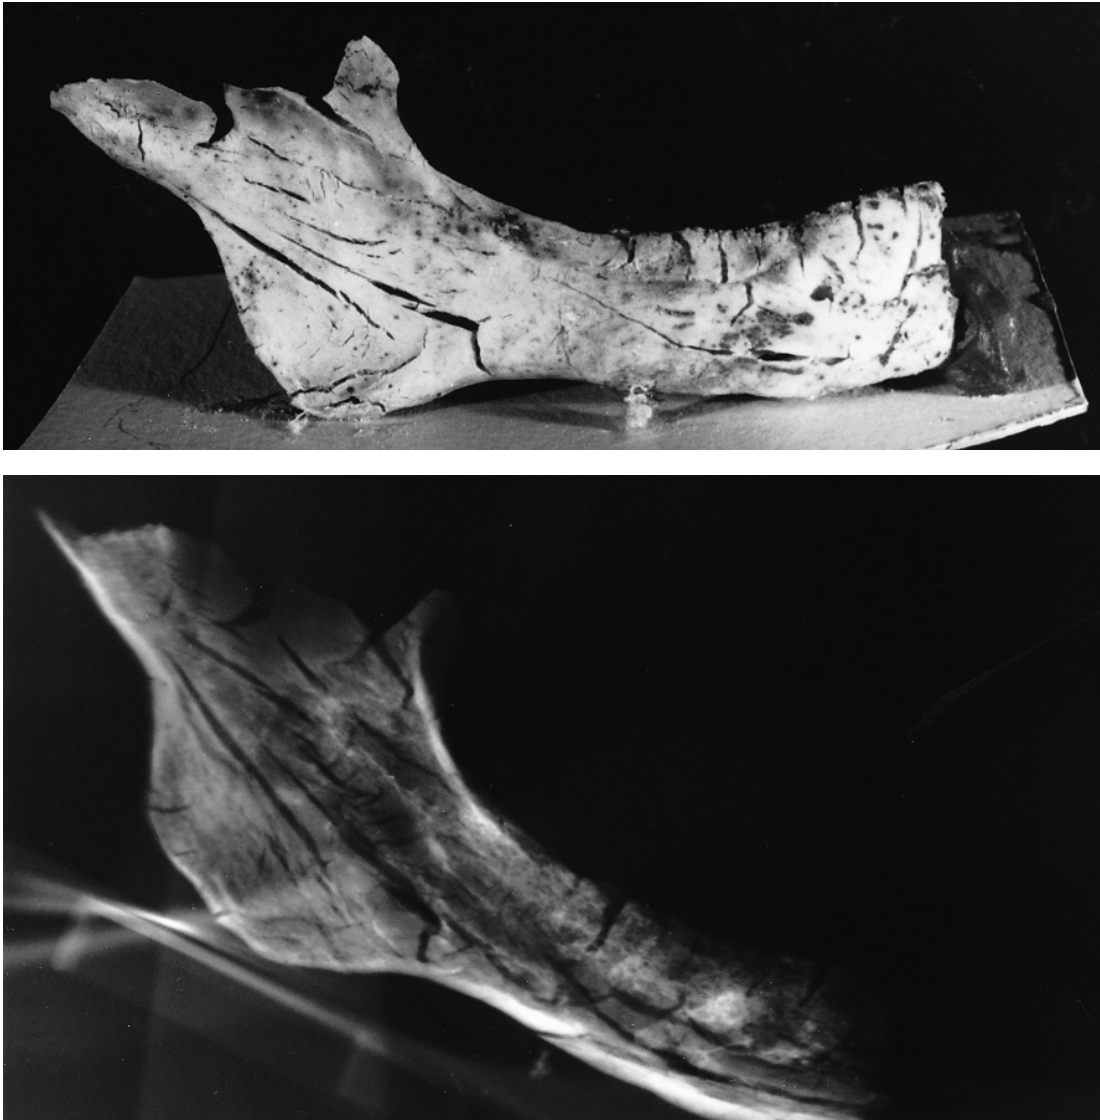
Right mandible from bin B-12. *Top*: photograph of the bone; *bottom*: radiograph of the bone. Natural size.
